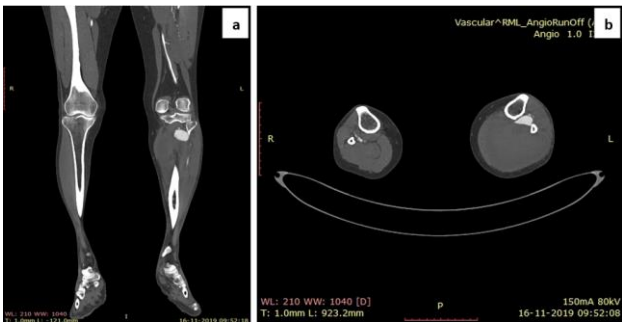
a) and b) Stab injury left leg: CT angiography of a pseudoaneurysm of peroneal artery with a large haematoma posteriorly.
